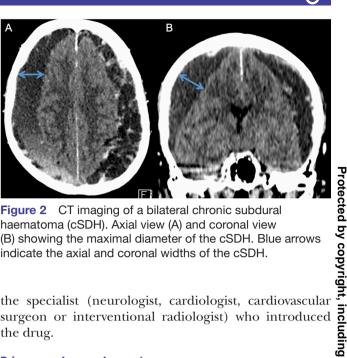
CT imaging of a bilateral chronic subdural haematoma (cSDH). Axial view (A) and coronal view (B) showing the maximal diameter of the cSDH. Blue arrows indicate the axial and coronal widths of the cSDH.
